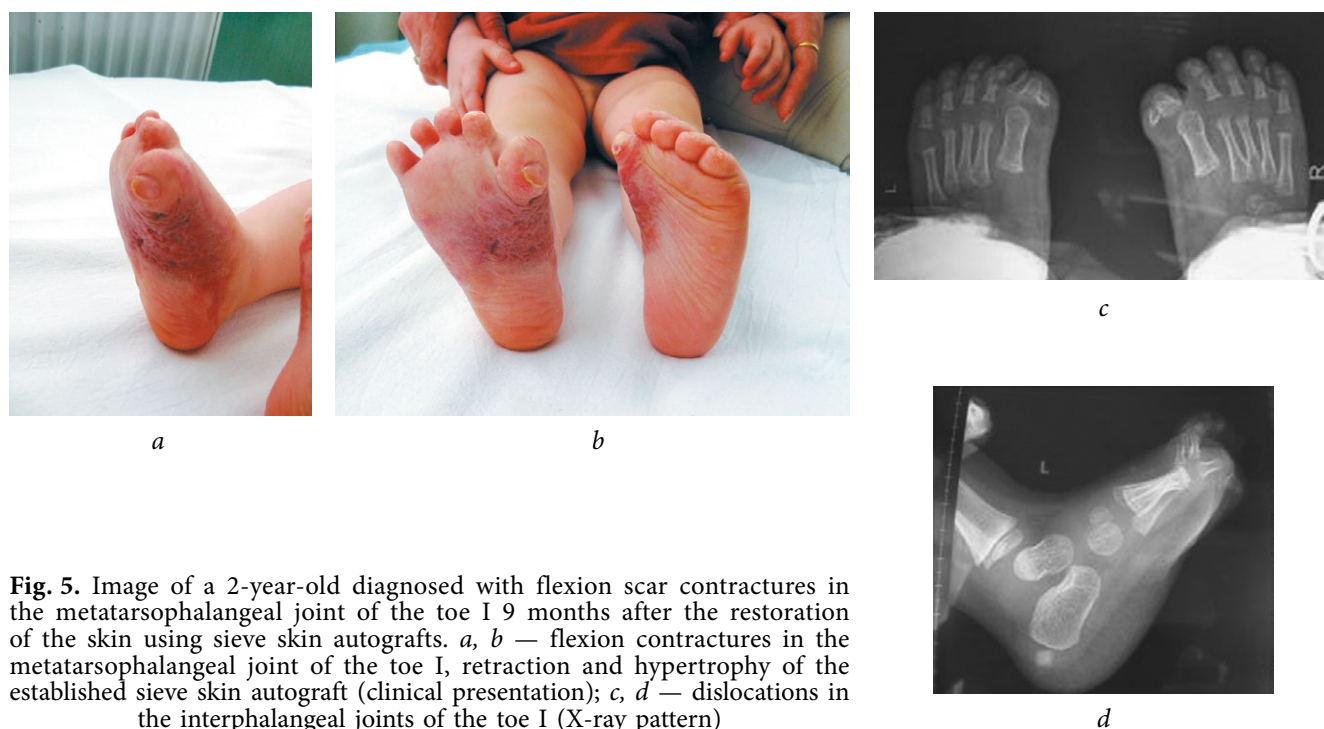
Image of a 2-year-old diagnosed with flexion scar contractures in the metatarsophalangeal joint of the toe I 9 months after the restoration of the skin using sieve skin autografts. *a, b* — flexion contractures in the metatarsophalangeal joint of the toe I, retraction and hypertrophy of the established sieve skin autograft (clinical presentation); *c, d* — dislocations in the interphalangeal joints of the toe I (X-ray pattern)
